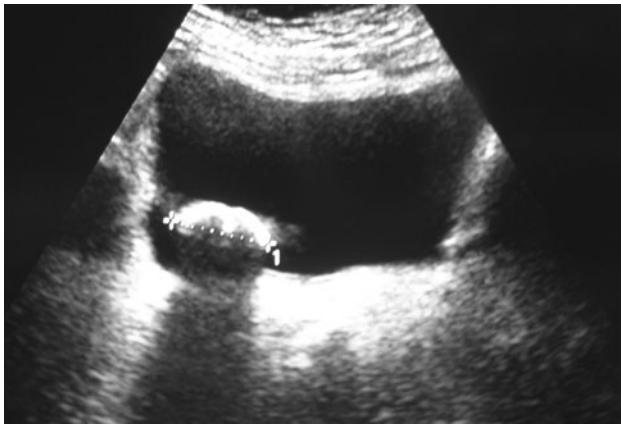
Intra-bladder lithiasis on right lateral wall shown by abdominal ultrasound imaging
